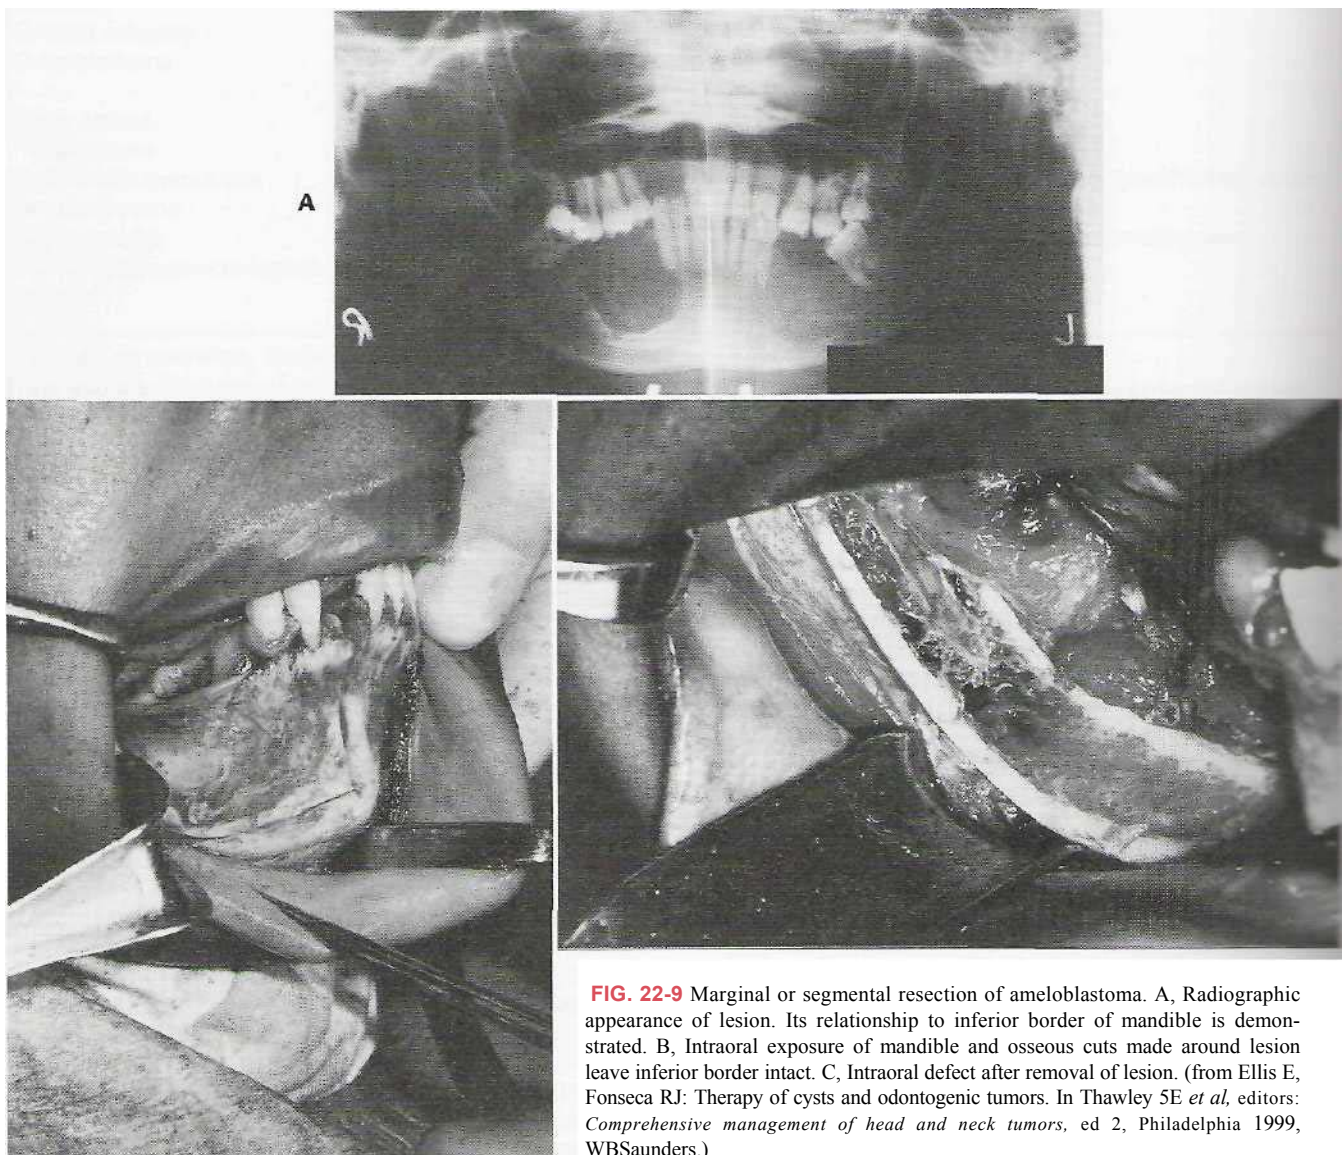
Marginal or segmental resection of ameloblastoma. A, Radiographic appearance of lesion. Its relationship to inferior border of mandible is demonstrated. B, Intraoral exposure of mandible and osseous cuts made around lesion leave inferior border intact. C, Intraoral defect after removal of lesion. (from Ellis E, Fonseca RJ: Therapy of cysts and odontogenic tumors. In Thawley SE *et al*, editors: *Comprehensive management of head and neck tumors*, ed 2, Philadelphia 1999, WBSaunders.)
